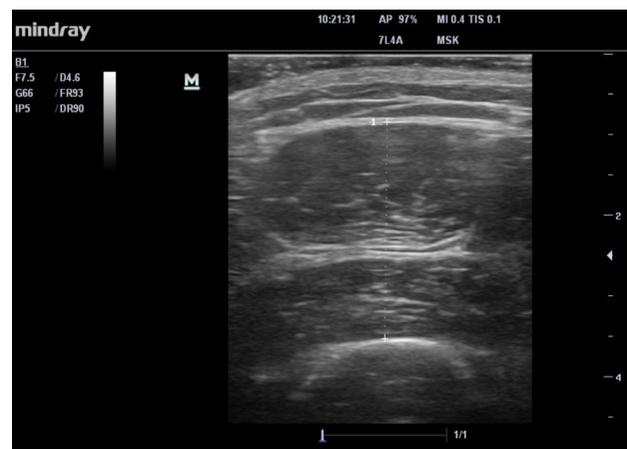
Anterior mid-thigh muscle thickness as measured by ultrasound
